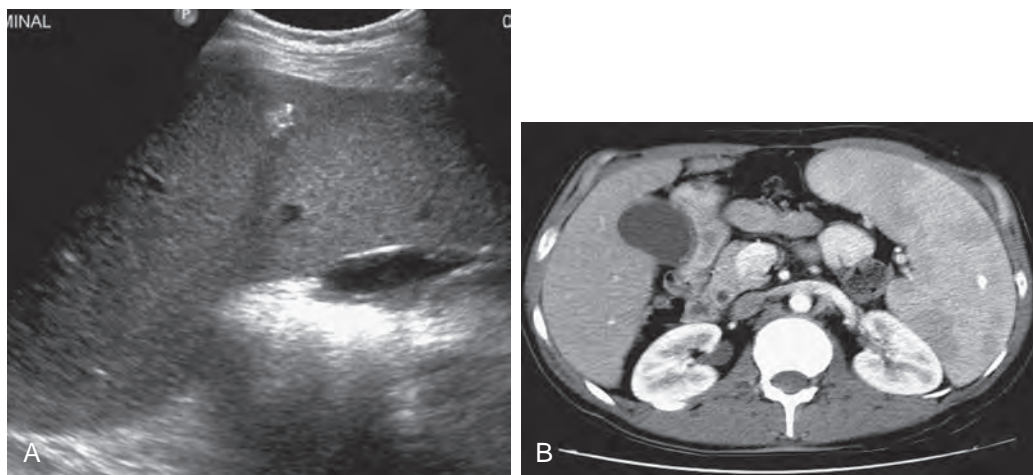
Burkitt's lymphoma in a 32-year-old man with AIDS. A. The sagittal sonogram demonstrates marked splenomegaly and parenchymal calcification. B. Enhanced helical CT scan during the portal venous phase demonstrates marked splenomegaly with inhomogeneous splenic texture and a calcification. The CT appearance suggests diffuse lymphomatous infiltration.
